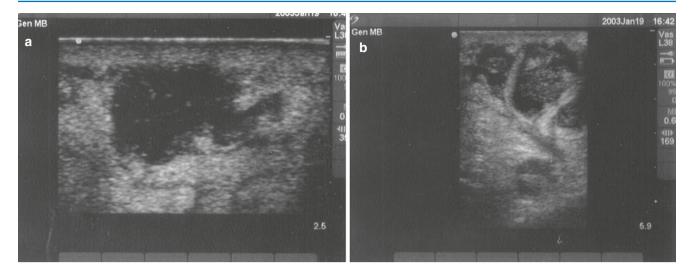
(a) Example of an abscess as viewed on bedside ultrasound. (b) A multiloculated abscess
